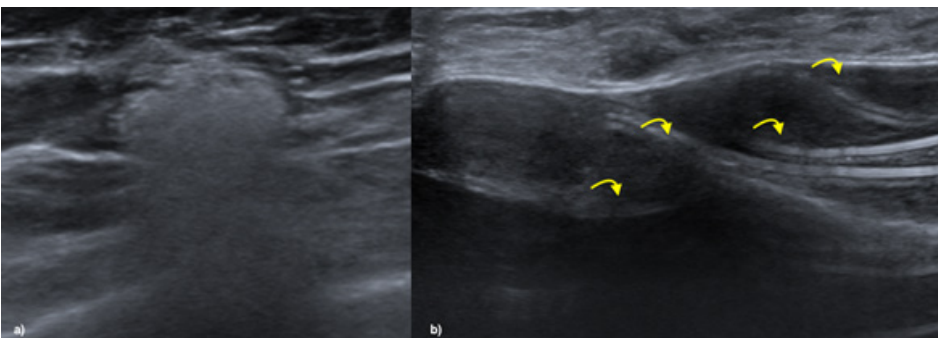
A 40-year-old woman with a history of breast augmentation. The ultrasound study identified the presence of axillary ganglion with sign of the “snowstorm”, suggestive of extracapsular rupture, confirmed by the presence of the “ladder” sign in the homolateral implant, translating intracapsular rupture.
